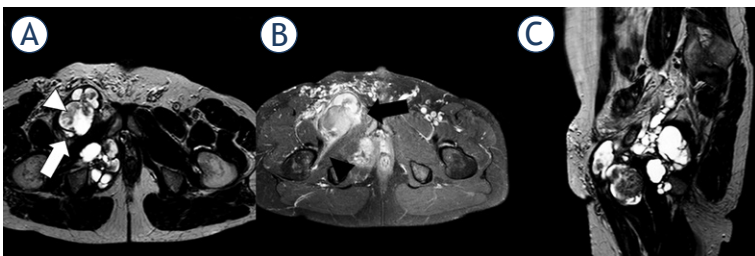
1.5-T MRI of the pelvis (A) proton density [PD] axial, (B) contrast-enhanced T1 fat saturation [FS] axial, (C) PD sagittal) of a 49-year-old patient. The higher-grade polycyclic/multilobulated sarcoma in the right pelvis (white arrow) shows heterogeneous contrast enhancement (black arrow), infiltrative behavior (black arrowhead), and solid components within cystic tissue (white arrowhead).
